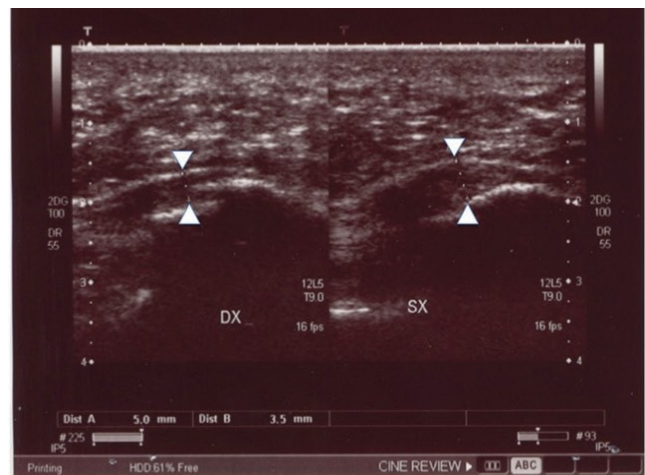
Pretreatment ultrasound scan, clinical case 1: The ultrasound study shows a thickening and enhanced hypoechoogenicity of the calcaneal insertion of the plantar fascia, which is more pronounced on the left, consistent with fasciitis (the arrows indicate the thickness of the tendon at the insertion).
